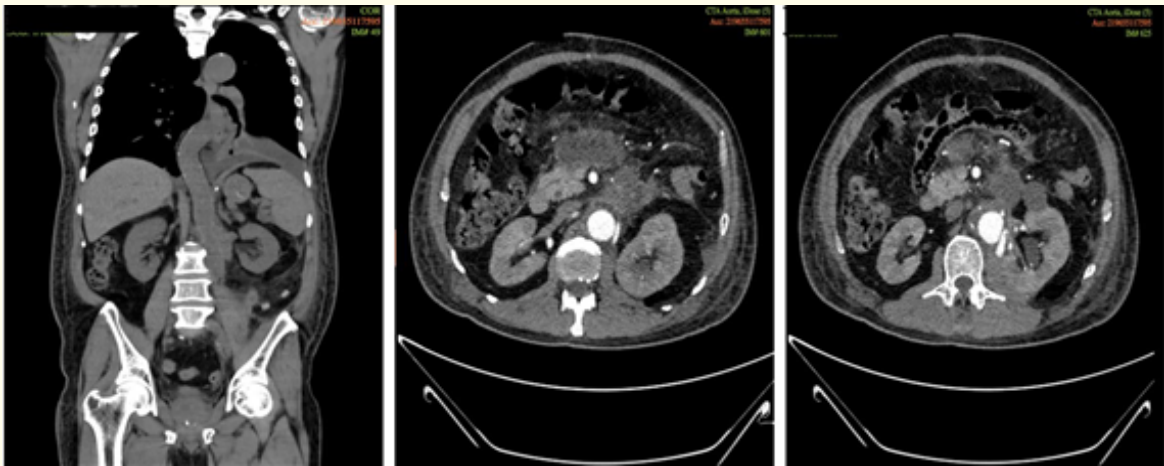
CT aortogram post-AAA repair showing that the previously noted infrarenal pseudo-aneurysm/aneurysm no longer seen. No IV contrast leak in the region of aortic surgery. The aortic anastomosis site is patent with no contrast extravasation at the time of examination. The rest of the aorta is atherosclerotic. The left internal iliac artery is occluded from its proximal segment. The inferior mesenteric artery is not visualized.
